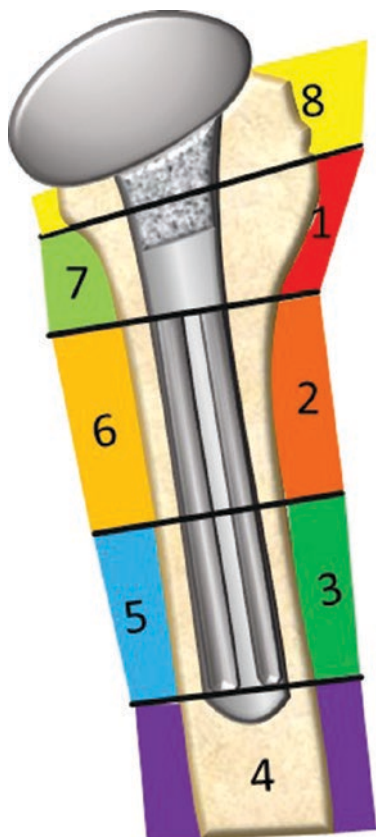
Eight radiographic zones to evaluate humeral ingrowth
